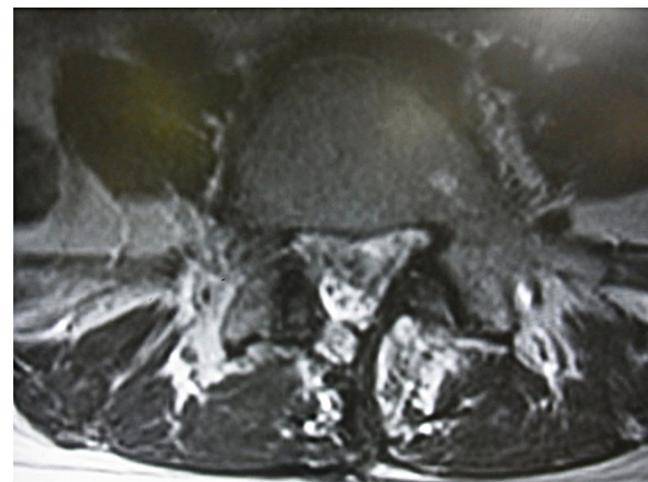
MRI showed a large disk herniation at L4/5 on the left paracentral of the spinal canal at 32 weeks gestation.
